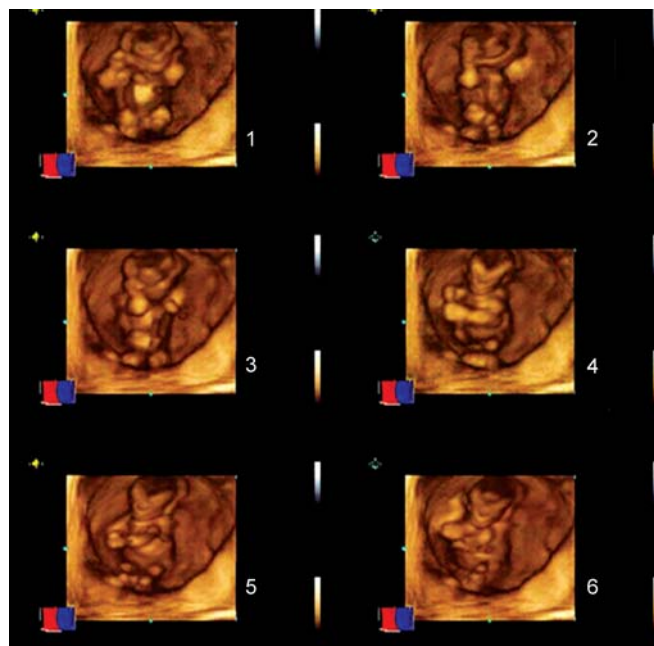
A sequence of images of the fetus at 9 weeks of gestation recorded by 4D sonography showing general movements
